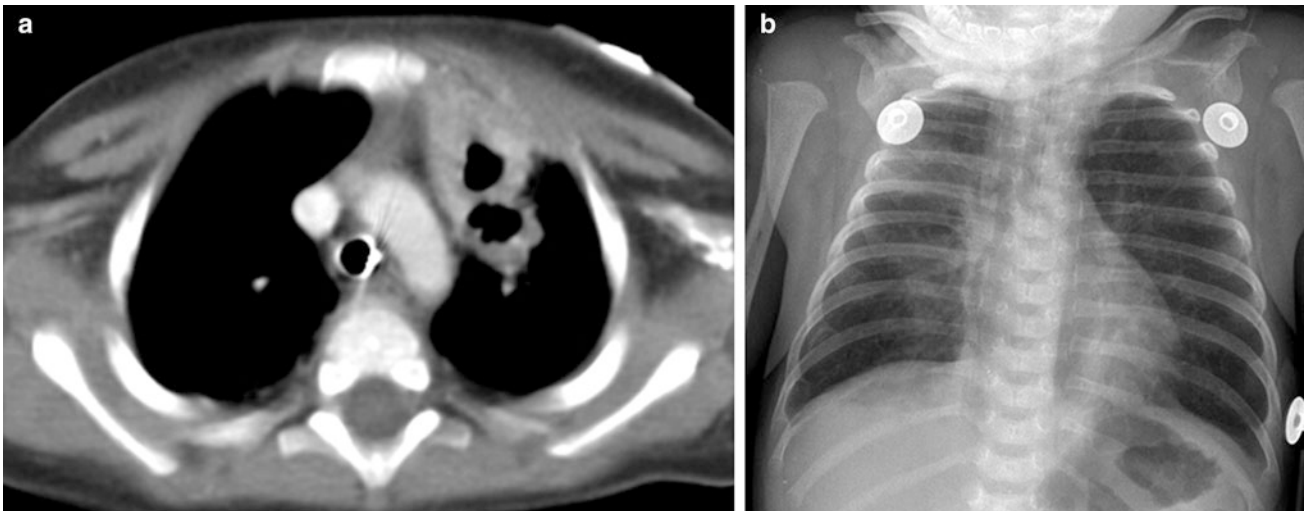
Severe combined immunodeficiency (SCID). An axial contrast-enhanced chest CT image (a) in a 6-year old with SCID demonstrates a paucity of thymic tissue in the anterior mediastinum, along with cavitary lesions in the anterior left upper lobe related to
